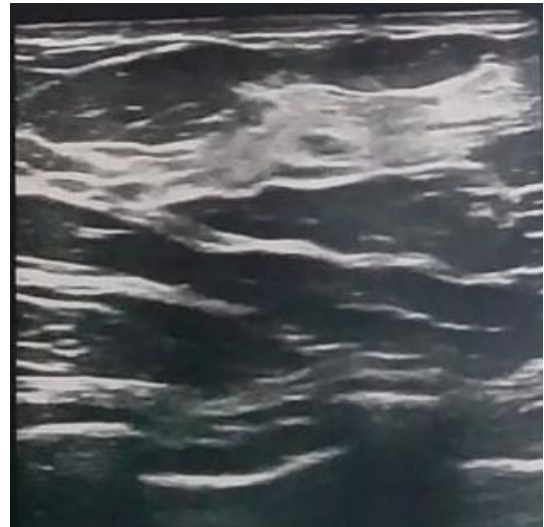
Breast ultrasound
